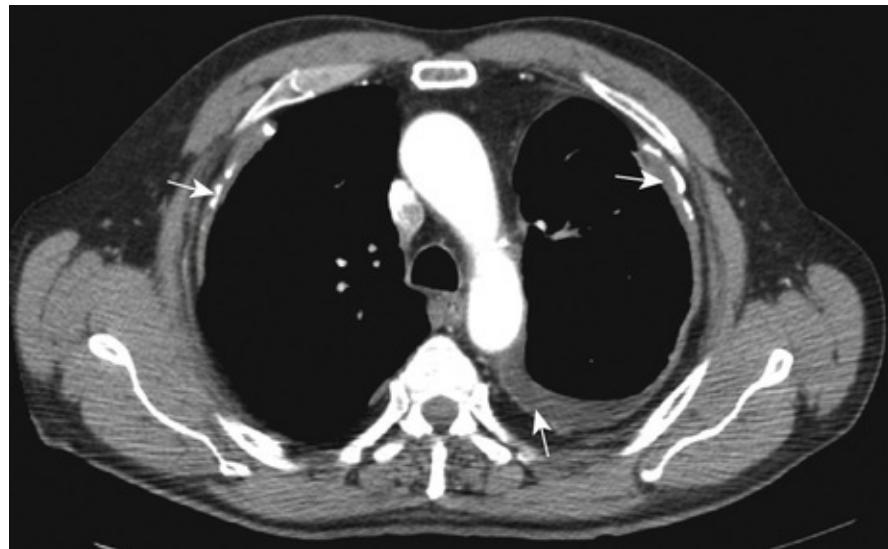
CT of a patient with a history of asbestos exposure and an abnormal CXR. You can see areas of thickened pleura as a grey line on the edge of the lung (bottom arrow), showing benign-type pleural effusion. White areas in some parts of thickened pleura can be seen; these are calcified pleural plaques (top arrows).
